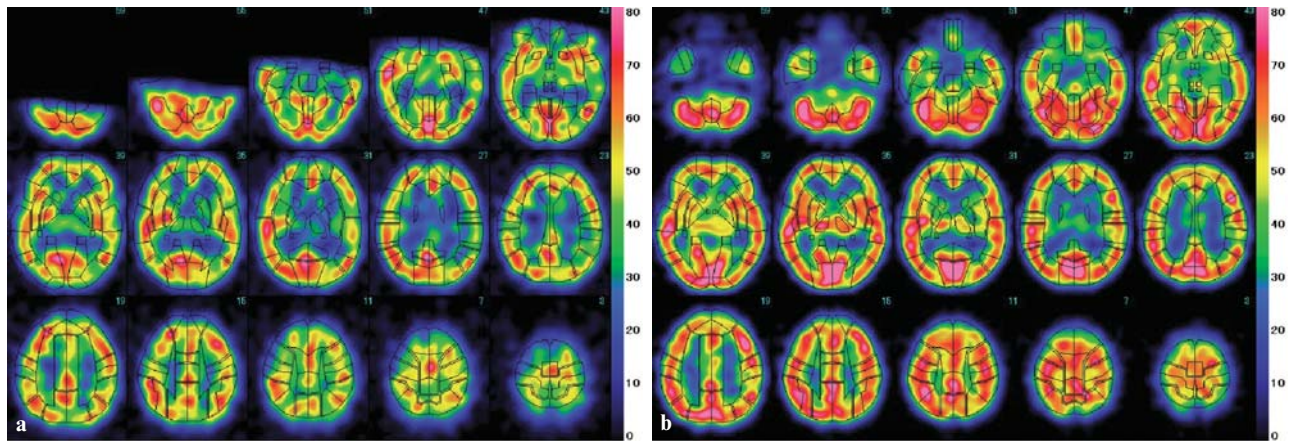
a FineSRT results from the preoperative post-Acz CBF SPECT images of the 8-year-old girl with moyamoya disease. CBF was hardly increased after Acz administration in the bilateral hemisphere. b FineSRT results from the post-EDAS post-Acz
